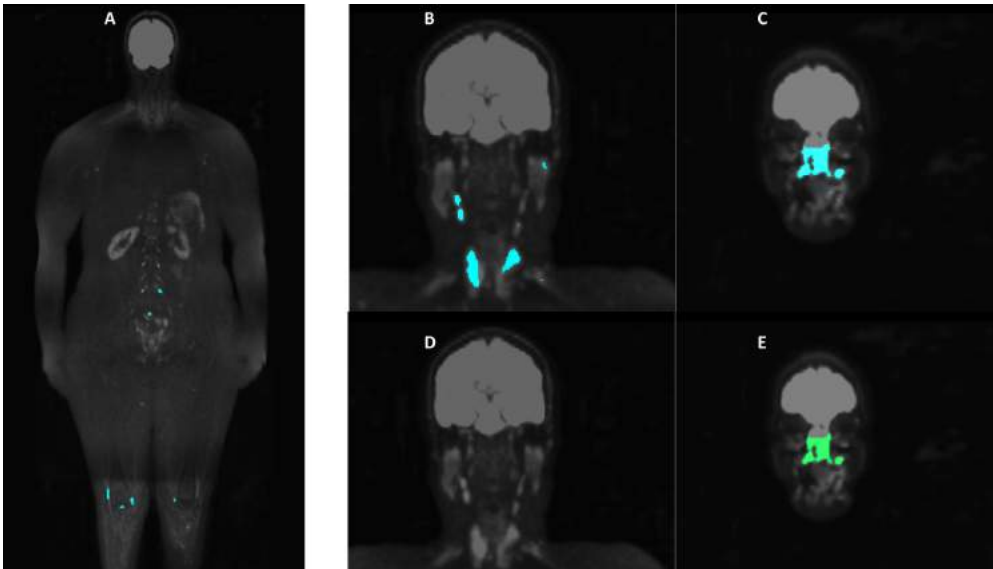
Smart segmentation coronal results of Case 3 (female). Sub-image A shows a representative coronal slice of the outlier segmentation applied to the 1000 s/mm^2 b-value DWI image. The normal hyperintense organs are correctly removed and no lesions are detected on the skeleton. There are small regions detected that are not part of the skeleton: spinal nerves, knees, neck glands (B) and sinus liquid (C). Sub-images D and E display the same zoomed coronal slices of B and C, using the connected-component approach applied to the 1000 s/mm^2 b-value image. The neck glands are removed but the sinus liquid remains.
